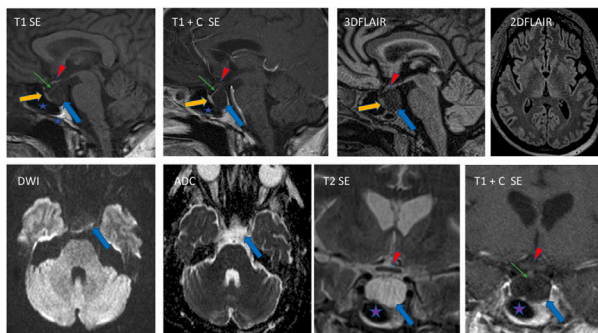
Intrasellar cystic structure (blue arrow) that causes anterior displacement of the adenohypophysis (orange arrow) and bilateral hyperintensity of the thalamus in FLAIR. Pituitary stalk (green arrow). Optic chiasm (Red arrow).
